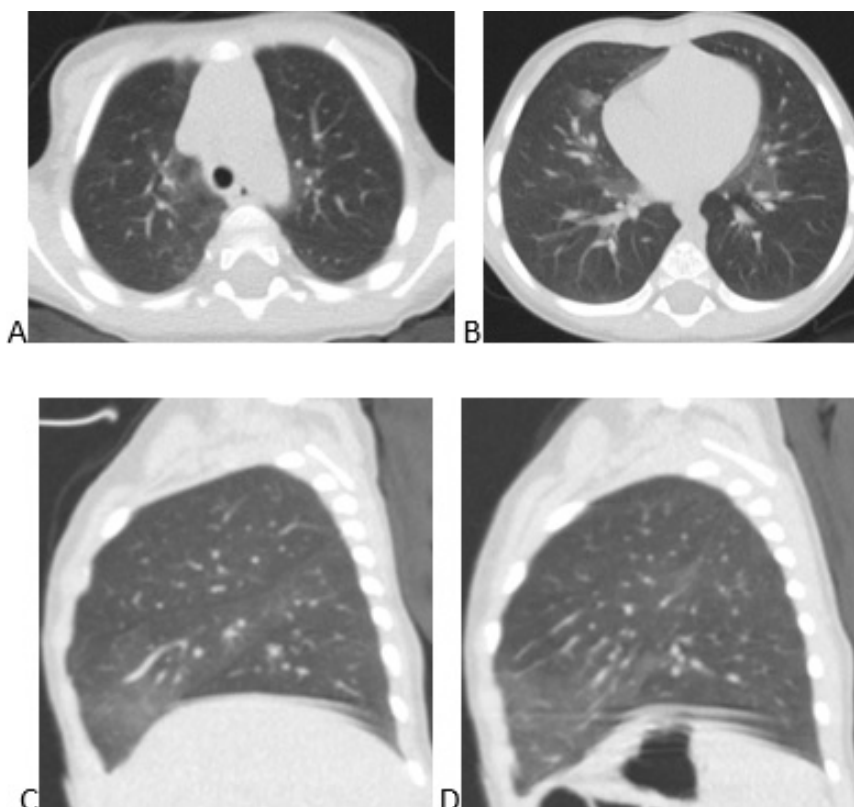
Chest CT axial images, at the level of aortic arch (A) and at the level of the heart (B), and sagittal reformations, of the right lung (C) and of the left lung (D)
